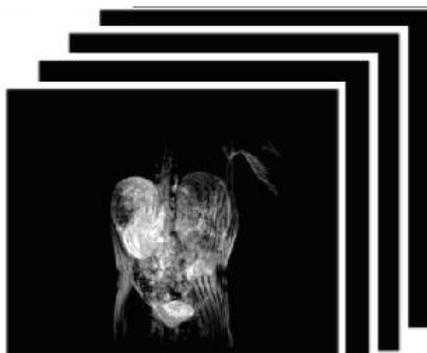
Images from MRI
